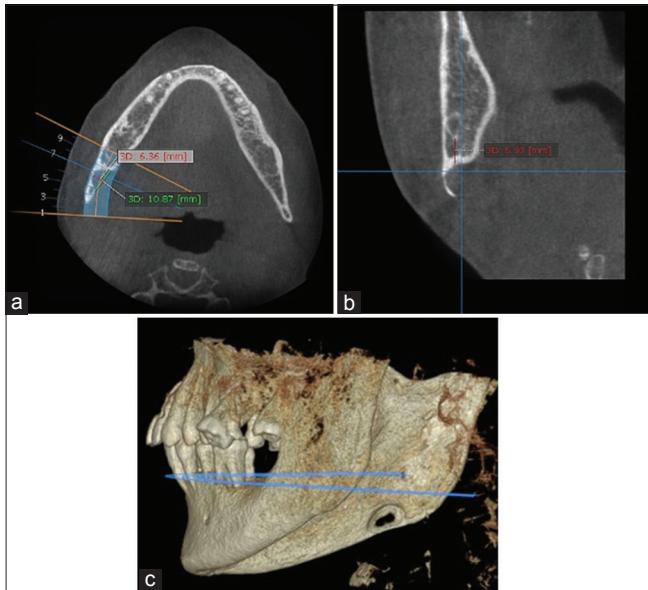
(a) Cone-beam computed tomography showing axial view, (b) coronal view, (c) and three-dimensional view of lingual bone cyst
